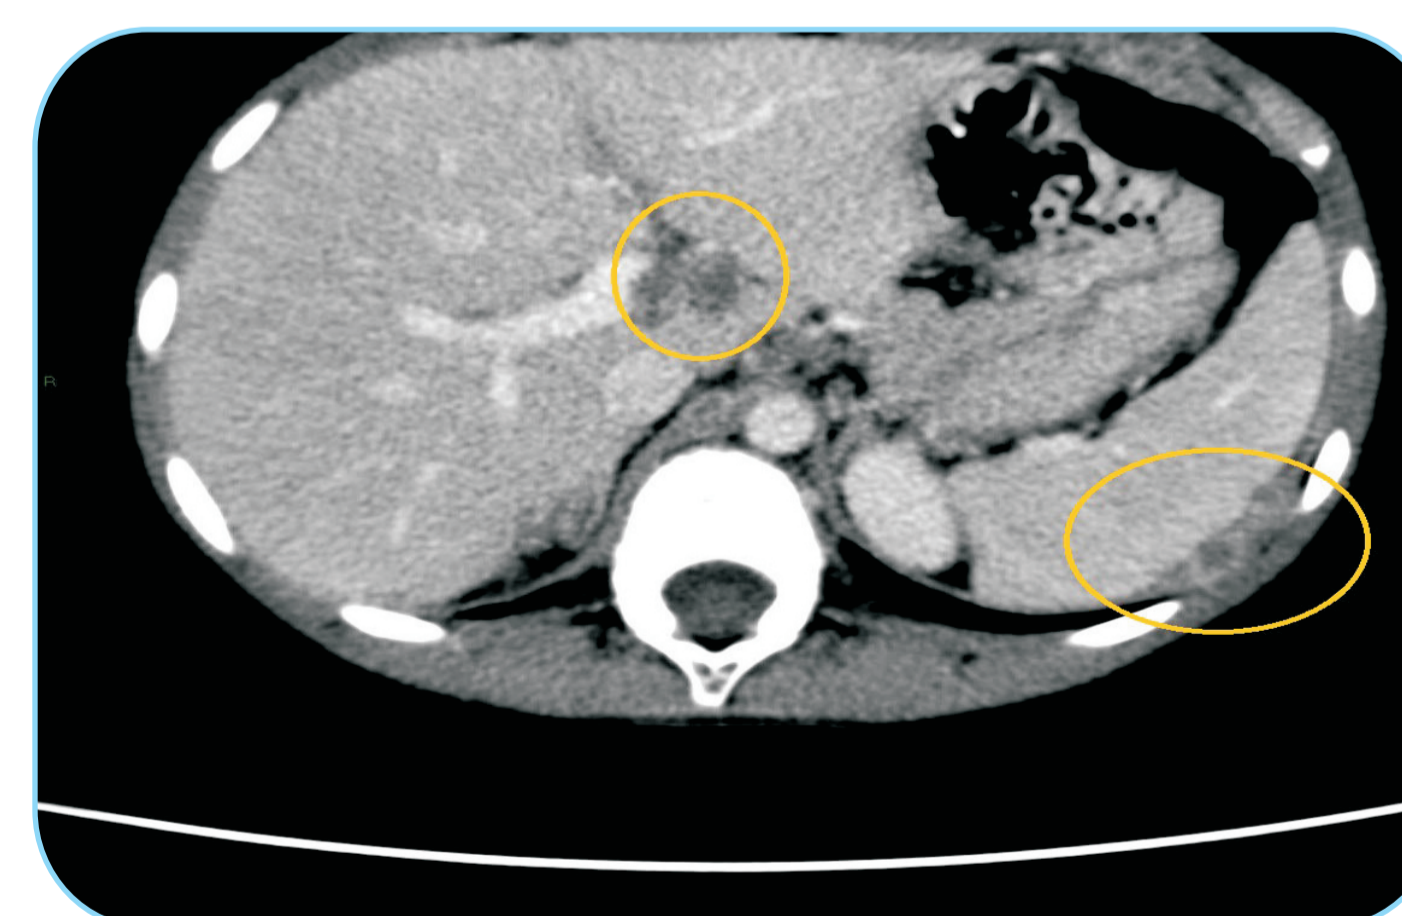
CT abdomen. August, 2016.
